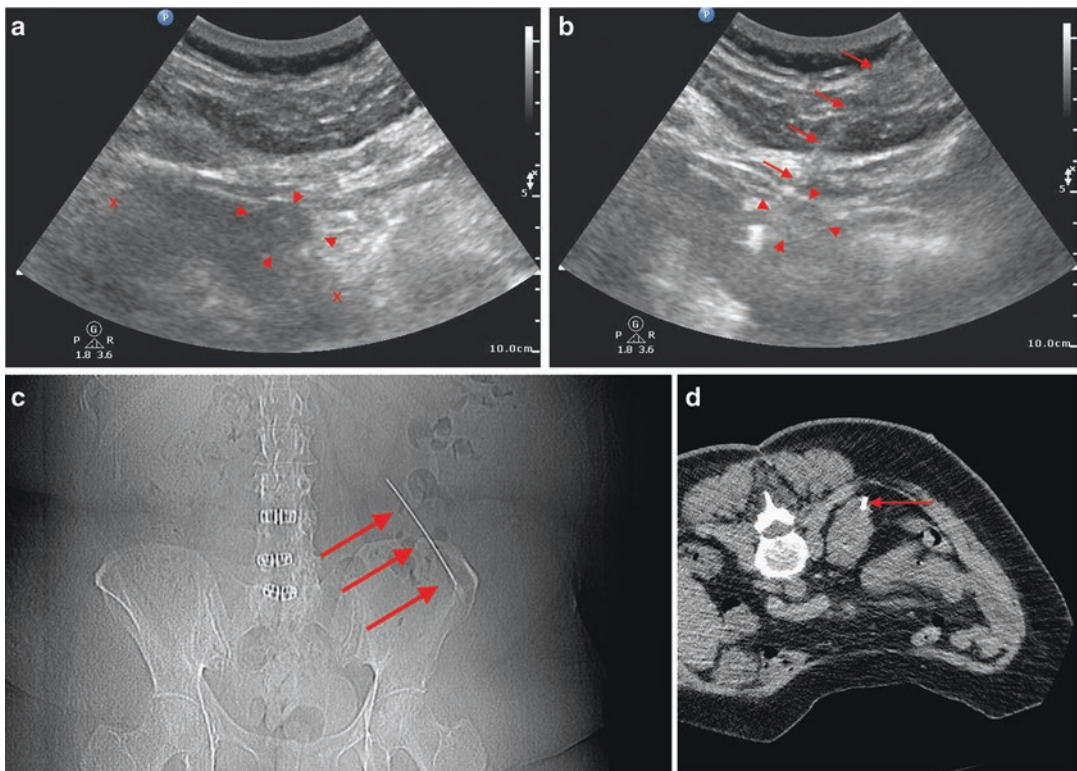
Imaging of ultrasound-facilitated computed tomography-guided percutaneous cryoablation. (a) Long axis ultrasound image of the left kidney. Xs indicate superior and inferior poles of kidney. *Solid arrowheads* delineate borders of the cortical neoplasm. (b) Long axis ultrasound image of the left kidney. *Solid arrows* mark the cryoprobe traversing subcutaneous fat, muscle, and perirenal fat with tip of the first cryoprobe within the superior
